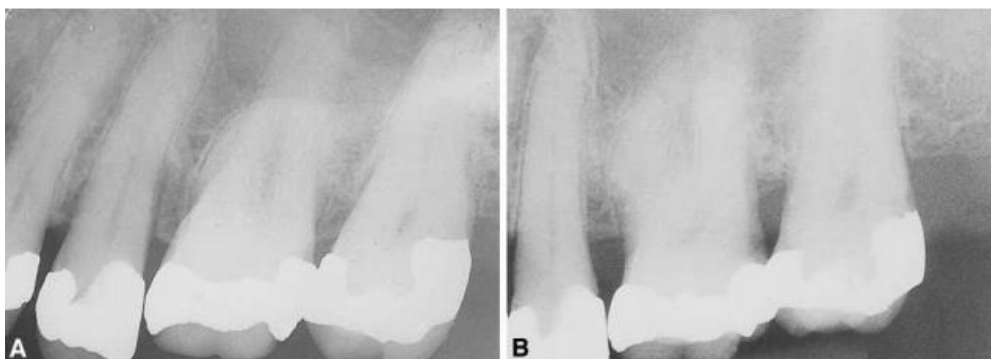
Radiographs (A) and a parallel long-cone method (B). Note distortion of interdental bone on bisecting angle radiograph.
